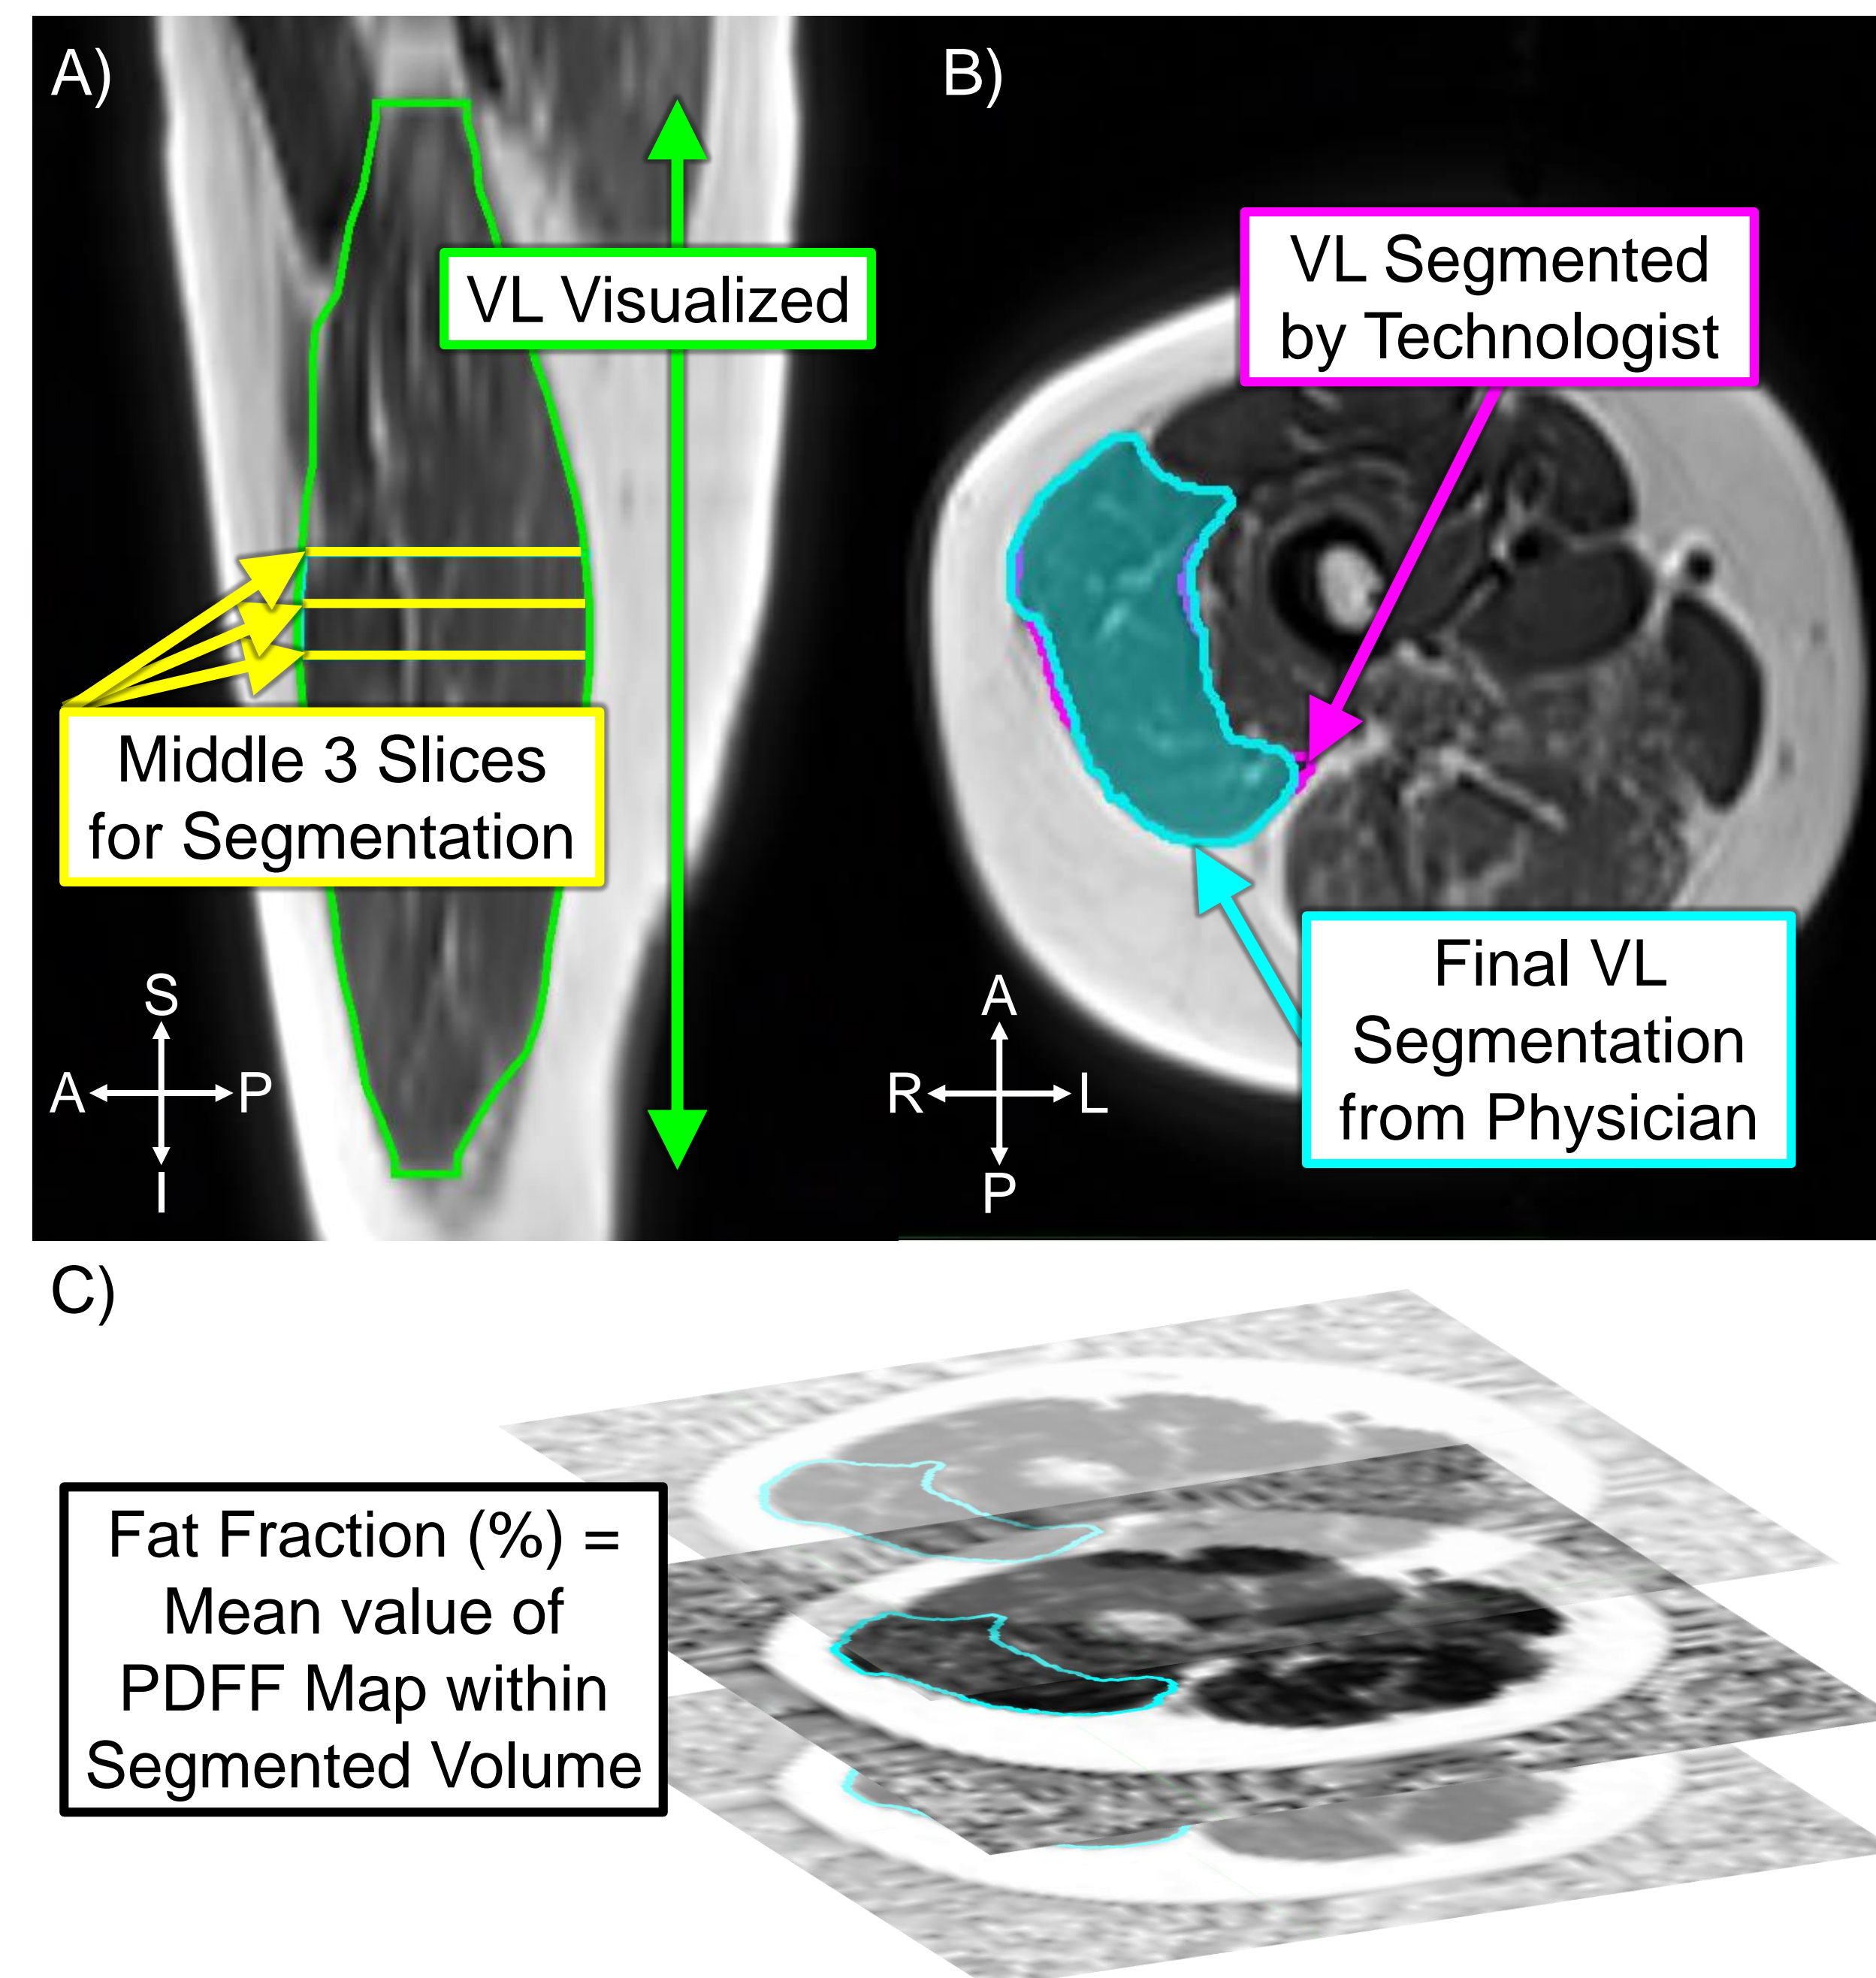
Computation of Fat Fraction. A) T1-weighted MRI of lower limb B) VL segmented by physician overread in T1-weighted images C) Fat fraction measured from PDFF map
